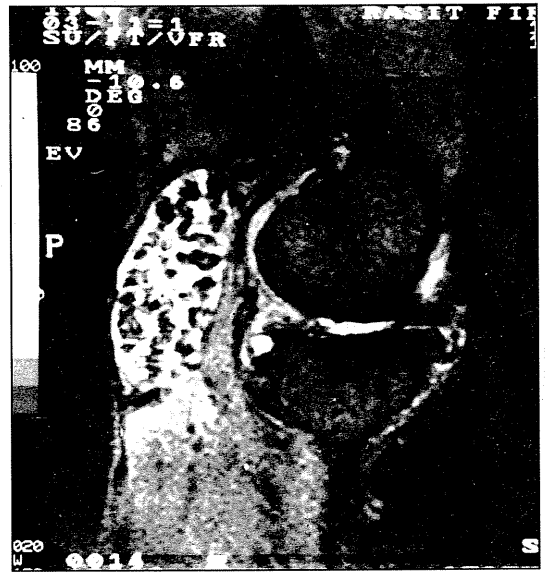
T2-weighted Image Shows Hyperintense Lesions and Joint Effusion*
